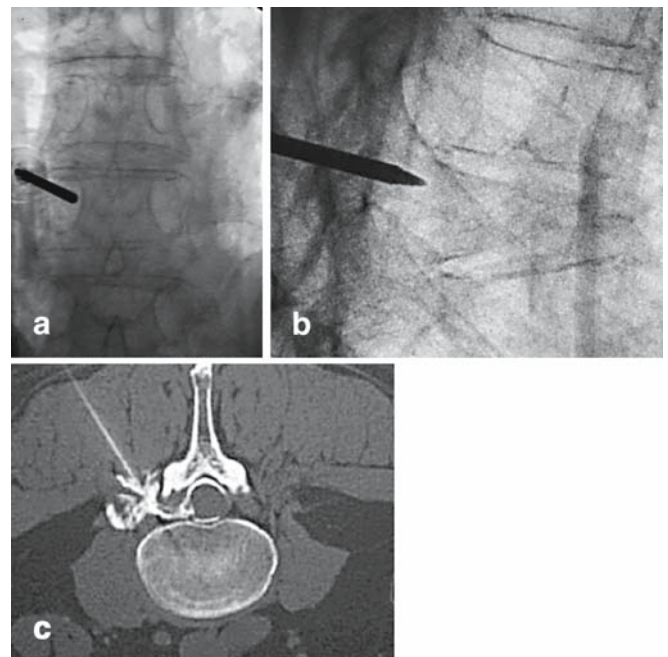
a,b Radiograph of an osteoporotic fracture with a needle in the fractured vertebra. c Computed tomography scan showing needle positioning
